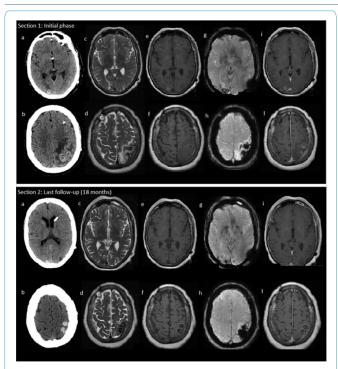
Section 1 shows neuroimaging findings in the initial phase: the brain CT scan shows haemorragic metastatic lesions in the right occipital and left parietal regions (a-b); the MRI shows haemorragic metastatic confluent lesions surrounded by vasogenic edema (c-f) with haemorragic components in subacute or chronic phases (g-h); Metastases were mildly and patchy enhancing gadolinium (i-l). Section 2 shows neuroimaging findings at the last follow up (18 months later - 28 months after complete resection of myxoma): we show a reduction of nodular lesions, in size, vasogenic oedema, contrast enhancement (a-b, c-d, i-l); any new haemorragic lesions was detected, while blood components were detectable as haemosiderine (g-h) Mixed with calcifications (a-b).
